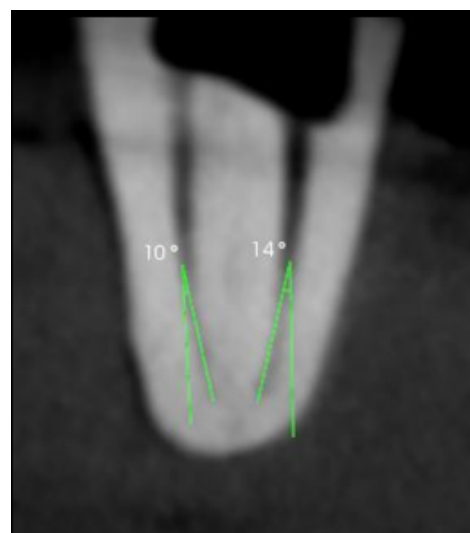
Calculating canal angulation of mesio-buccal & mesio-lingual canal using CBCT
